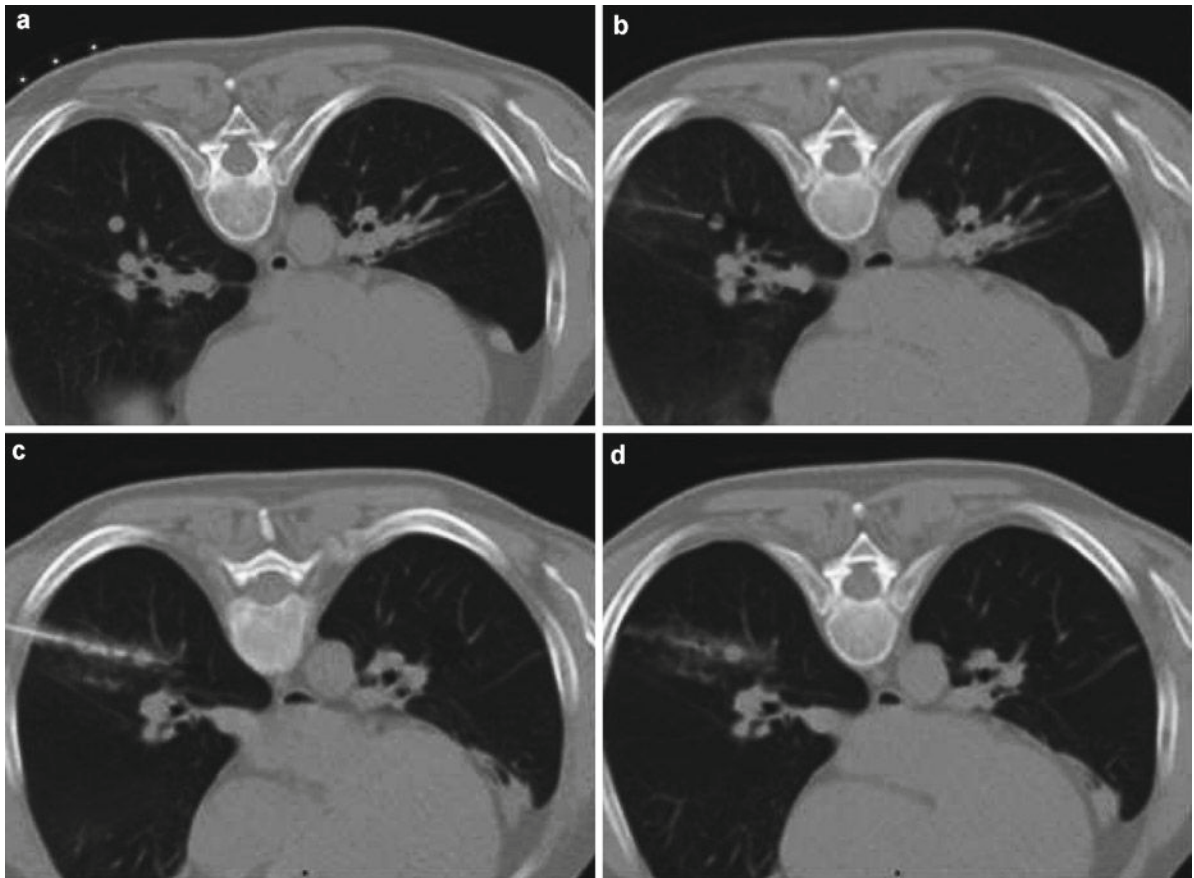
CT-guided biopsy in a patient treated for MALT lymphoma. The biopsy of the 8-mm nodule located in the lower right lobe showed a metastasis from an unsuspected melanoma
